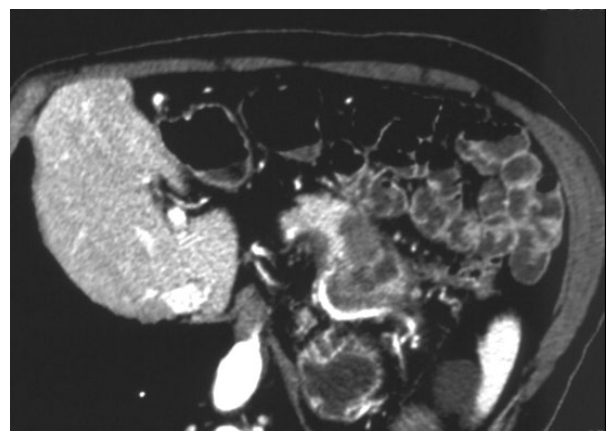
Multidetector computed tomography scan: pancreatic necrosis.
